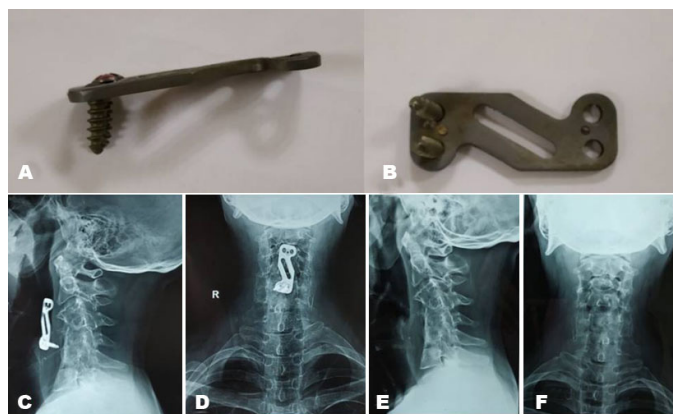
(A) and (B) are the expectorated implant construct from mouth. (C) and (D) X-ray cervical spine lateral and anteroposterior view showing implant in situ with two missing screws. (E) and (F) are the post-expectoration X-rays without the implants and there is good fusion.
